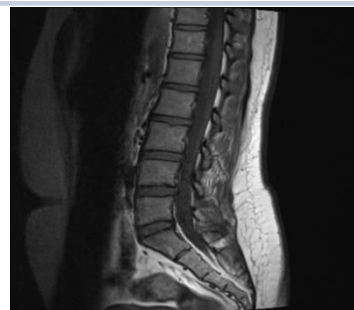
MRI T3 of lumbar spine shows normal study
